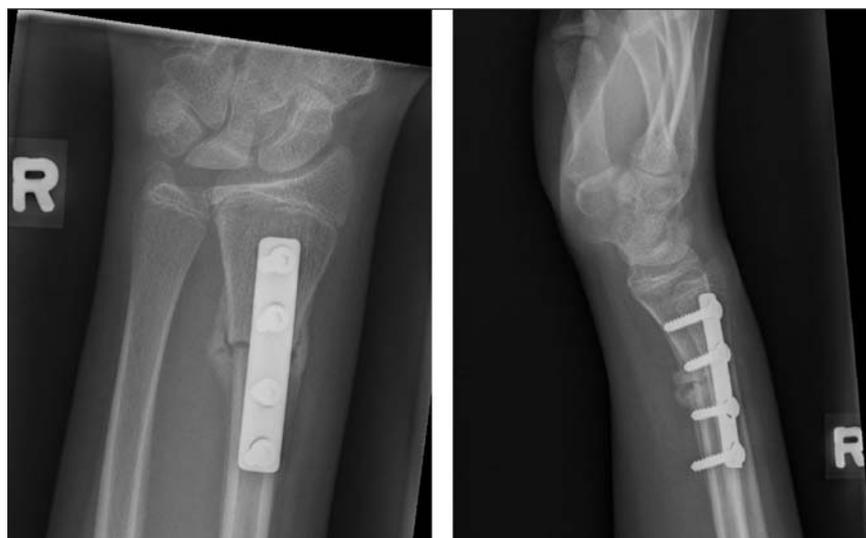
Anteroposterior (left) and lateral (right) radiographs 6 weeks postoperatively show progressive consolidation at the osteotomy site. The lunate bone appears to have increased height and density.
